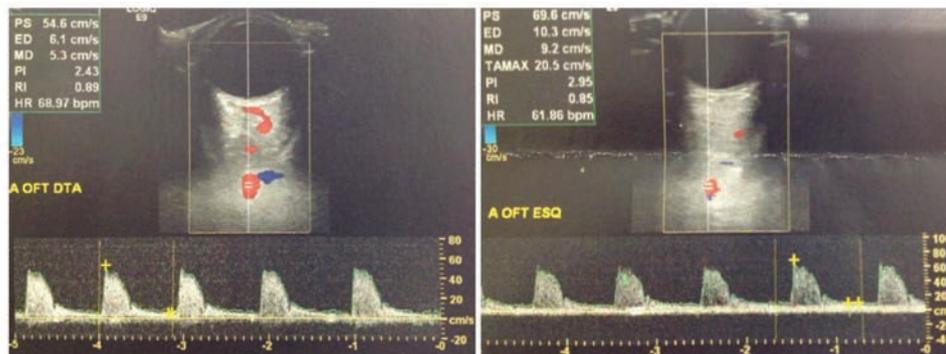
Ophthalmic Doppler of the right and left ophthalmic artery (after stent intervention).
